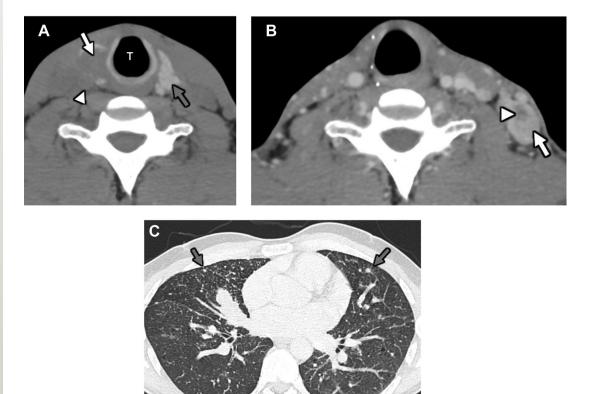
A 33-year-old man with 2-year history of diarrhea and palpable anterior neck mass. Calcitonin level was 26,000. (*A*) Unenhanced CT axial image at level of thyroid shows ill-defined hypodense mass located in posterior right thyroid (*white arrow*). No definite invasion of the trachea (T) or significant mass effect on the right common carotid artery (*white arrowhead*) is seen. Left thyroid is normal and hyperdense due to the intrinsic iodine (*gray arrow*). (*B*) CECT axial image after total thyroidectomy demonstrates metastatic cervical lymphadenopathy. The enhancing node (*white arrow*) has small central area of necrosis (*white arrowhead*). (*C*) Axial CT of chest demonstrates military pattern of thyroid metastatic disease (*gray arrows*). Patient also had extensive necrotic mediastinal lymphadenopathy and disease in spine and liver.
